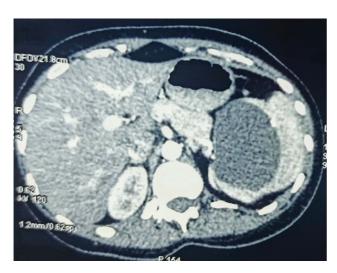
Contrast-enhanced computed tomography image showing the splenic cyst.
